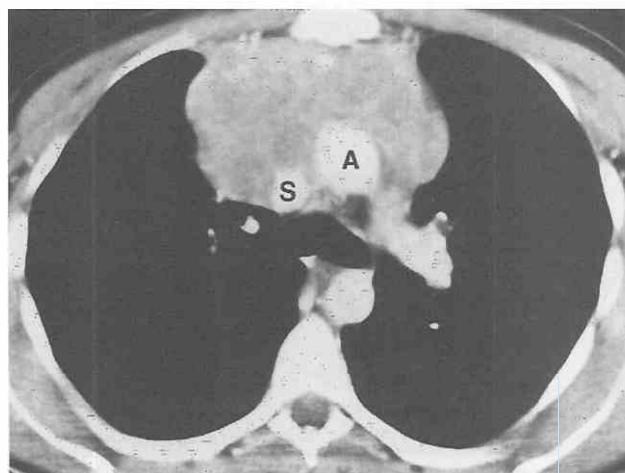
Thymic carcinoid. Contrast-enhanced CT shows large anterior mediastinal mass. The mass appears heterogeneous, and infiltration of mediastinum can be seen, with extension of the mass between vascular structures. A, aorta; S, superior vena cava.
